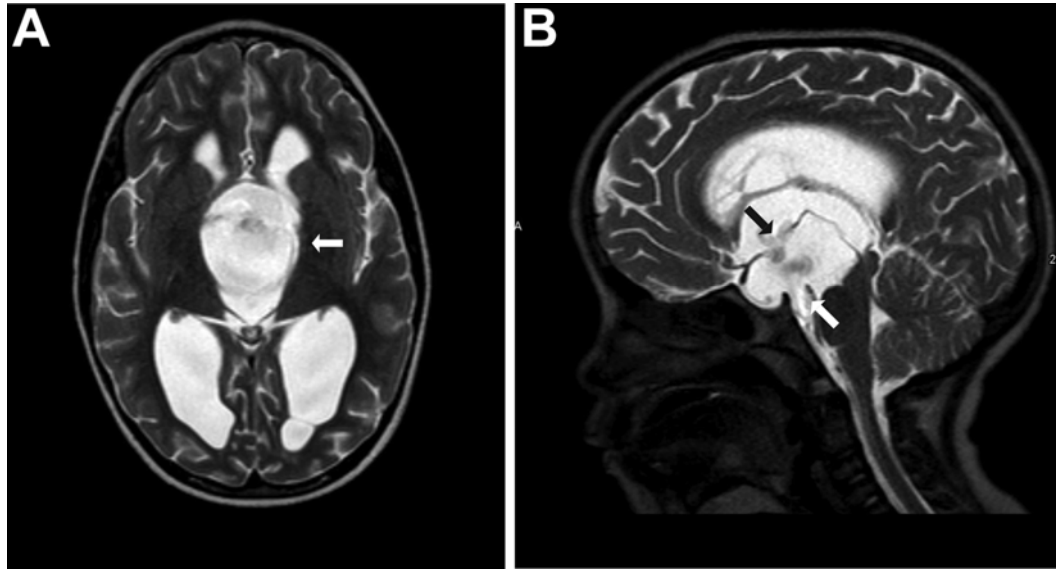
Pre surgical axial (A) and coronal (B) T2-weighted images demonstrating a large, thin-walled suprasellar cyst with dilatation of the lateral ventricles (*arrows*).
